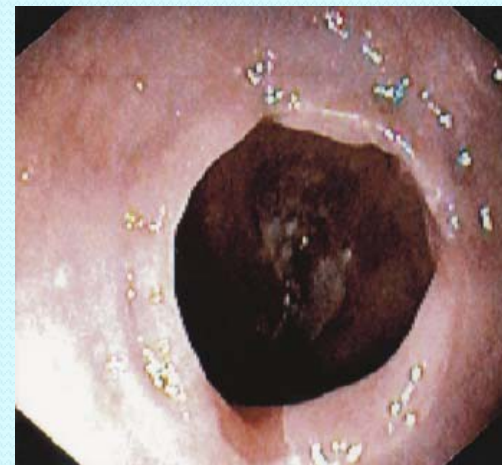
Schatzki's ring (A) with corresponding barium swallow x-ray (B) and endoscopic view (C)
